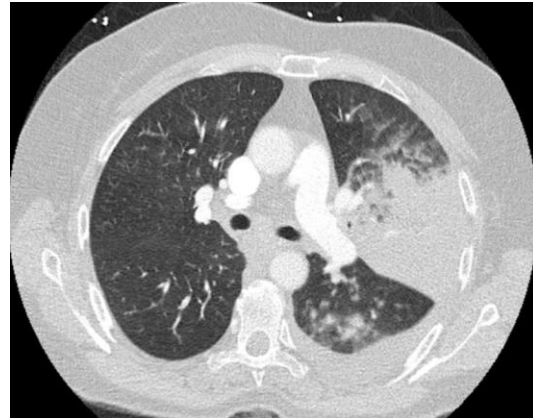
From case one, CT chest shows left upper and lower lobe consolidation with pleural effusion.
